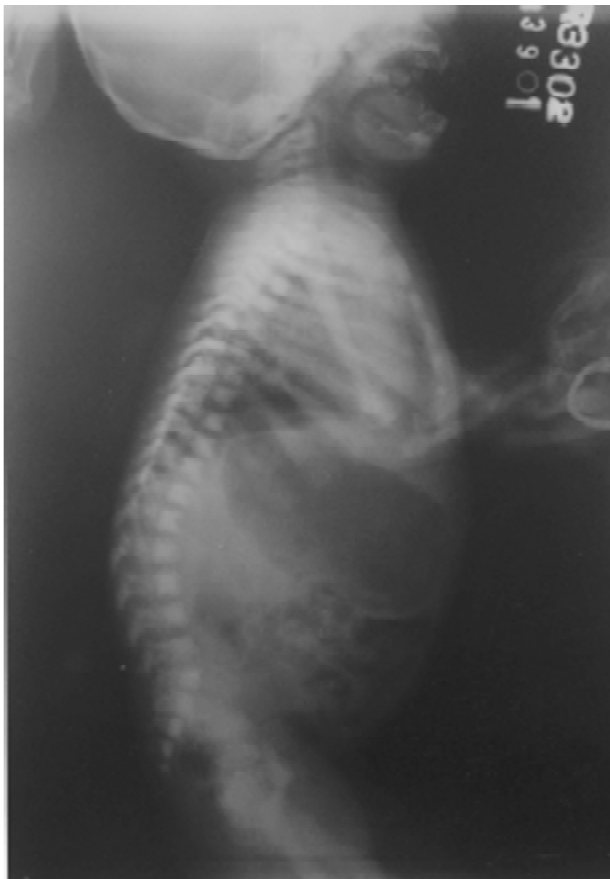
Radiograph of spine (lateral view) showing 'rugger jersey' appearance.
